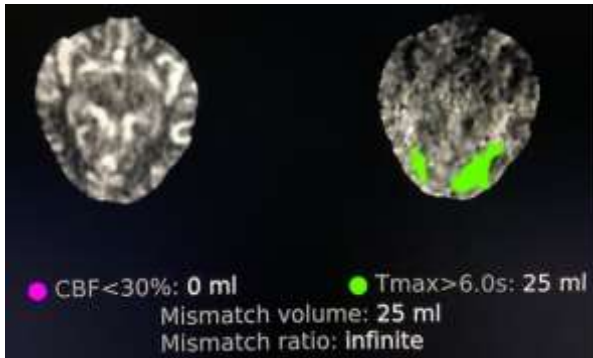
CT perfusion study showing mild bilateral posterior distribution ischemia ($T_{max} > 6$ secs) without matching core infarct ($CBF < 30\%$), interpreted by a neuroradiologist as possible artifact.
